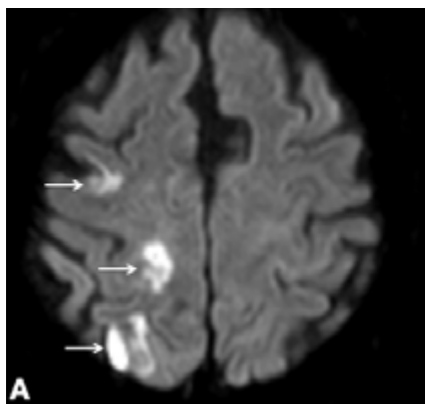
MRI of a 43-year-old man presenting with abnormal sensations on the left side. Acute cortical and white matter lesions in the right parietal and frontal lobes (arrows) demonstrate restricted diffusion, appearing hyperintense on diffusion-weighted imaging (A) and hypointense on apparent diffusion coefficient mapping (B).
